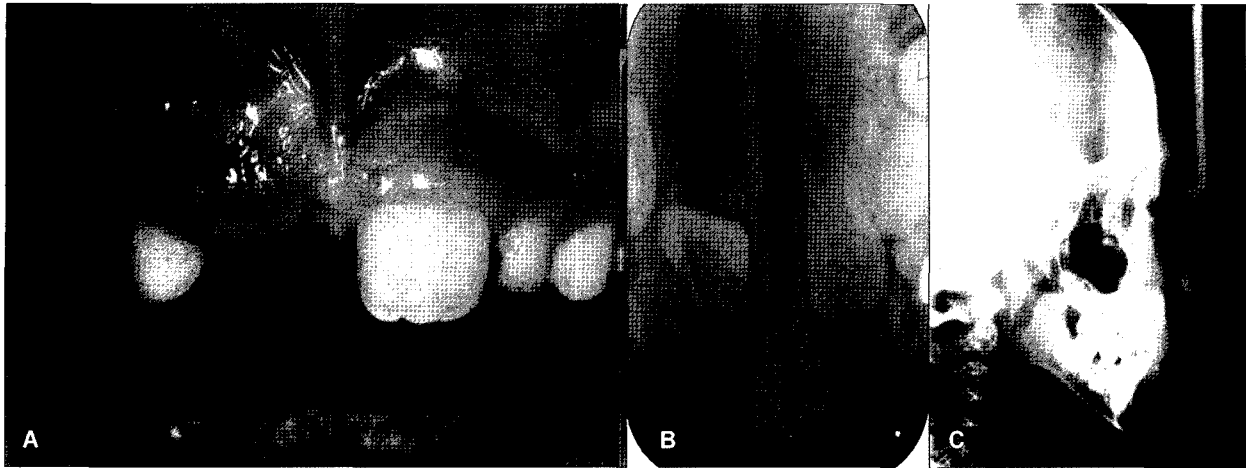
Pretreatment intraoral photograph (A), pretreatment periapical (B) and cephalometric radiograph (C).
